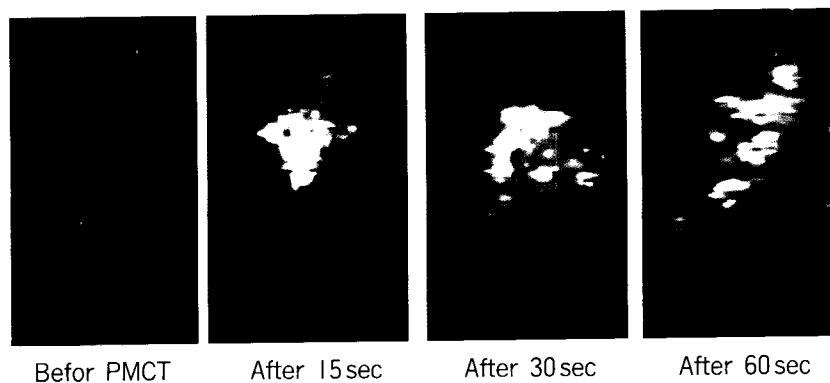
Changes in the color Doppler image of hepatocellular carcinoma 1 cm in diameter after percutaneous microwave coagulation therapy (PMCT).
